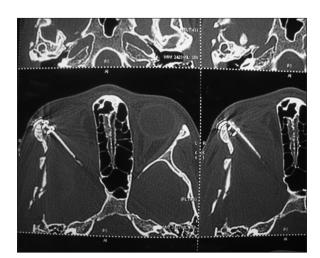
CT axial cut showing graft, plate, and screws in place
